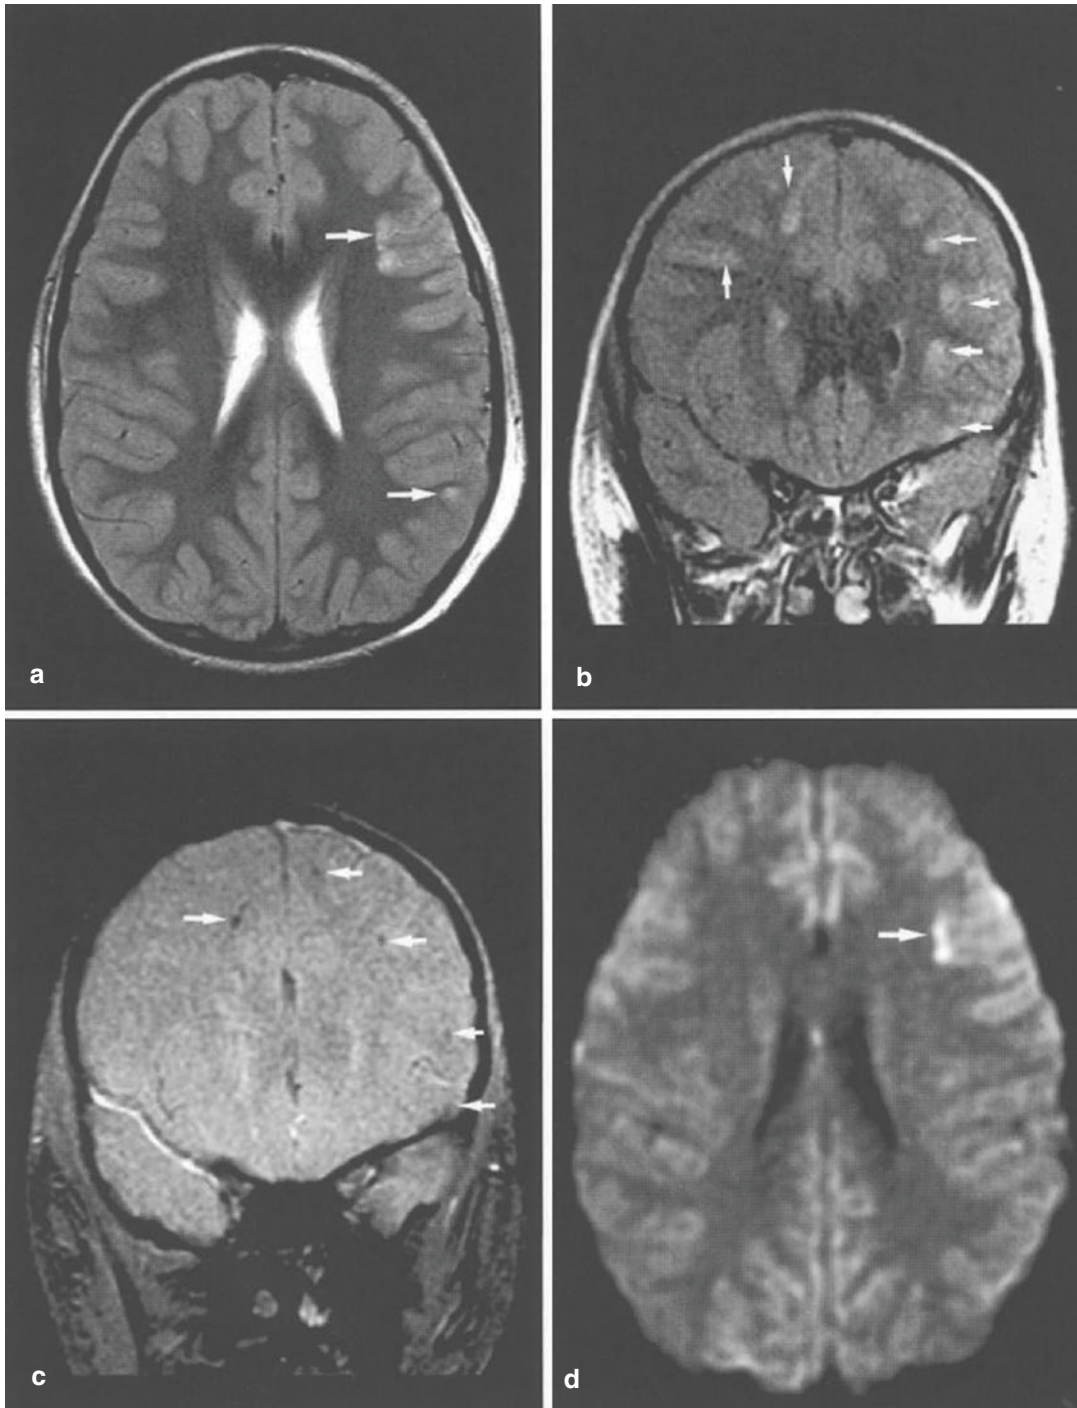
(a–d) Diffuse axonal injury in gray-white matter junction in a 7-year-old boy after a motor vehicle accident. (a, b) T2-weighted and coronal FLAIR images show multiple hyperintense lesions in the gray-white matter junction of bilateral frontoparietal lobes (arrows). (c)
